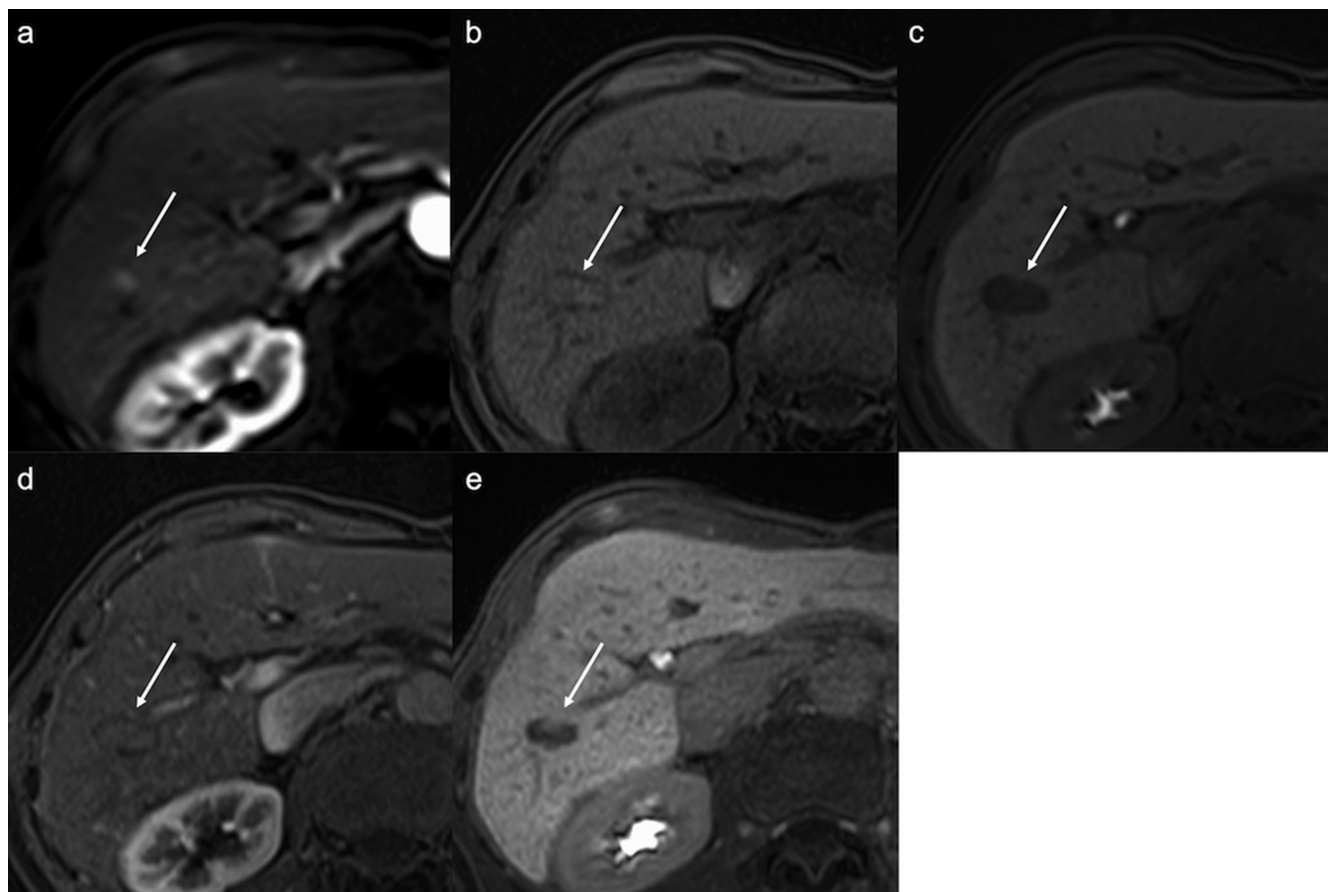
A 72-year-old male patient with hepatocellular carcinoma who underwent RFA. Pre-treatment gadoxetic-acid-enhanced MRI showed the hypervascular tumor in the segment VI (a, arrow). Five months after RFA, the tumor showed hyperintensity on the pre-contrast T1 weighted image (b, arrow), a hypointense area on hepatobiliary phase surrounded the tumor (c, arrow), and the arterial phase hyperenhancement disappeared (d, arrow), consistent with complete response according to mRECIST. One year after the treatment, the size of the hypointense area in the hepatobiliary phase decreased (e, arrow). mRECIST, modified response evaluation criteria in solid tumors; RFA, radiofrequency ablation.
